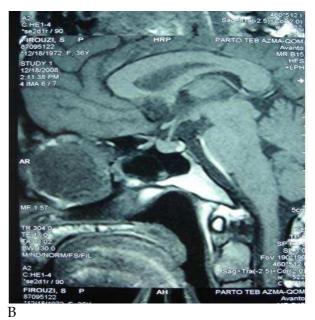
A: Coronal T2 weighted MRI image that reveals a mass in the right ethmoid and nasal cavity region.
